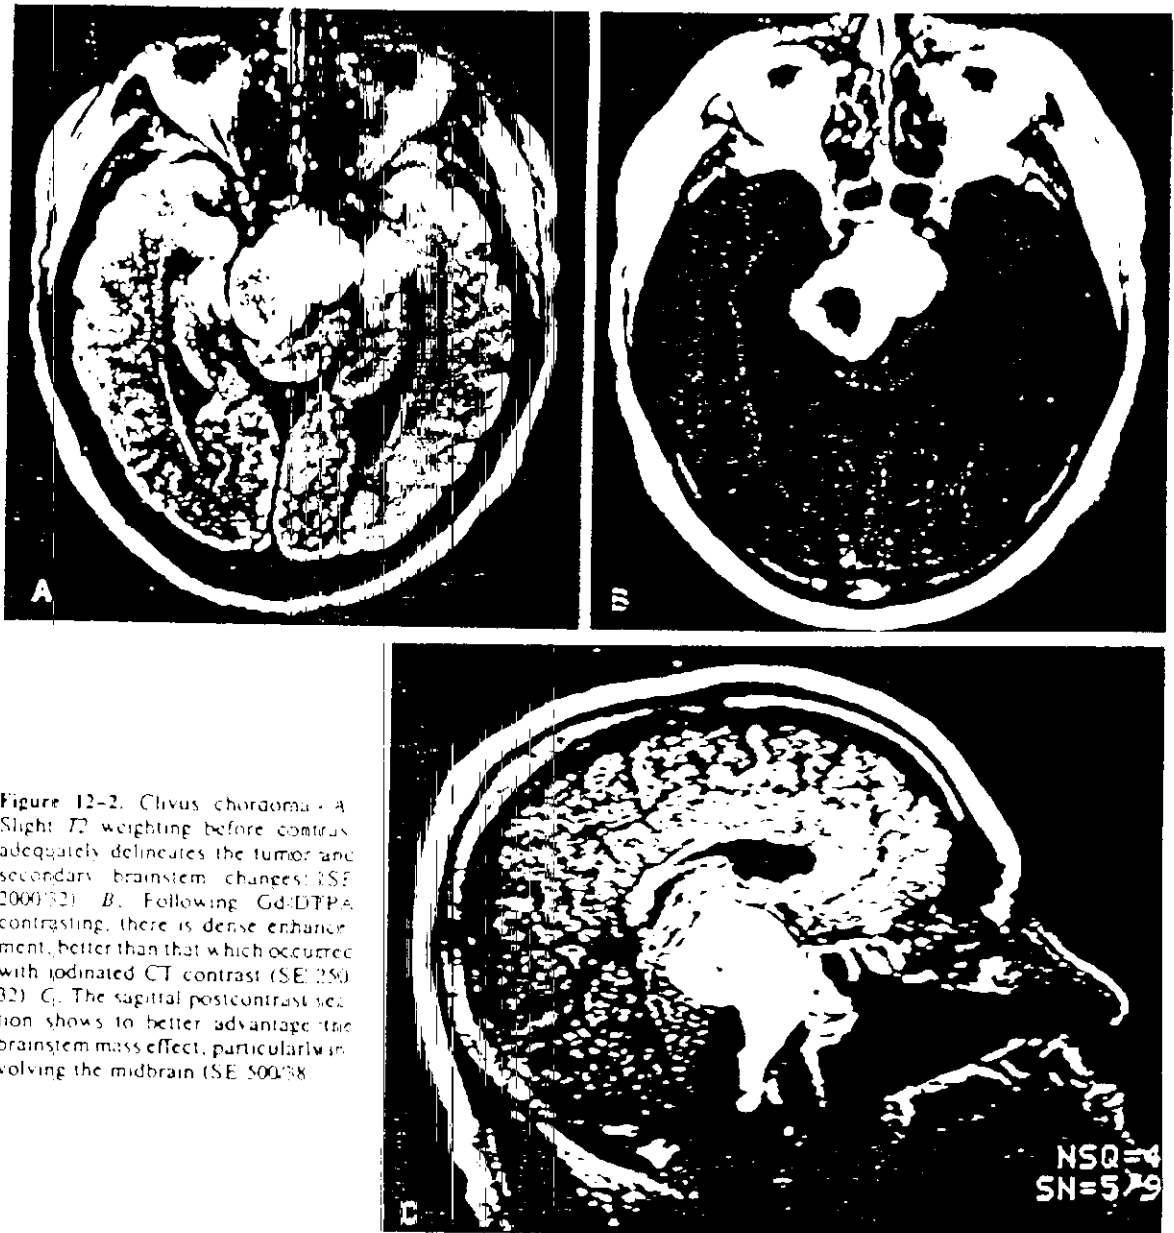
Clivus chordoma. A. Slight T_2 weighting before contrast adequately delineates the tumor and secondary brainstem changes (SE 2000/32). B. Following Gd-DTPA contrasting, there is dense enhancement, better than that which occurred with iodinated CT contrast (SE 250/32). C. The sagittal postcontrast section shows to better advantage the brainstem mass effect, particularly involving the midbrain (SE 500/38).
